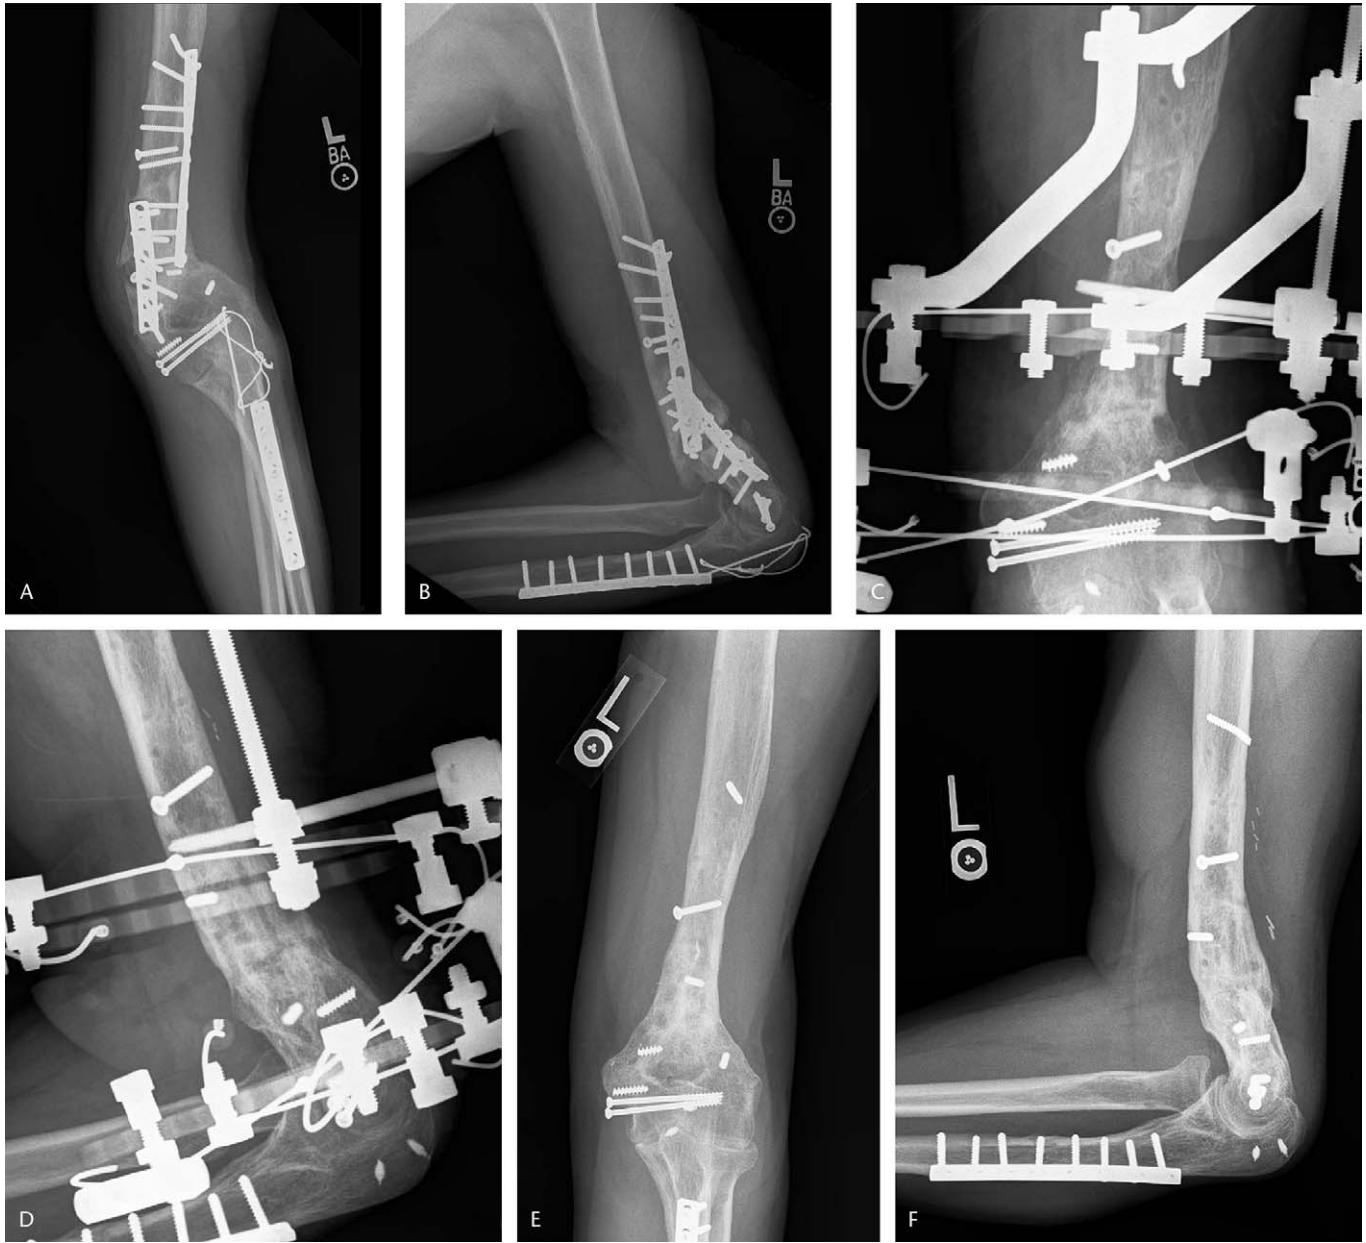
A and B, Presenting anteroposterior and lateral radiographs of an infected (grossly purulent) nonunion of a 33-year-old man (Case 3) 35 months after an open fracture of the distal humerus that was initially treated elsewhere by plate and screw fixation. The patient had undergone 1 attempt at plate and screw fixation and 1 bone graft procedure for treatment of his nonunion prior to being referred to us. At presentation, he rated his maximum pain as 6/10, had a DASH score of 51%, and self-rated his quality of life as "good." C and D, Radiograph during treatment showing compression at the nonunion site. E and F, Final radiographic result showing bony union following 224 days of Ilizarov external fixation. At 42 months follow-up, the patient had a 90 degree arc of motion with flexion to 110 degrees, no evidence of infection, a maximum pain of 1/10, a DASH score of 81%, and self-rated his quality of life as "very good" with a gain of 4 quality-adjusted life years.
